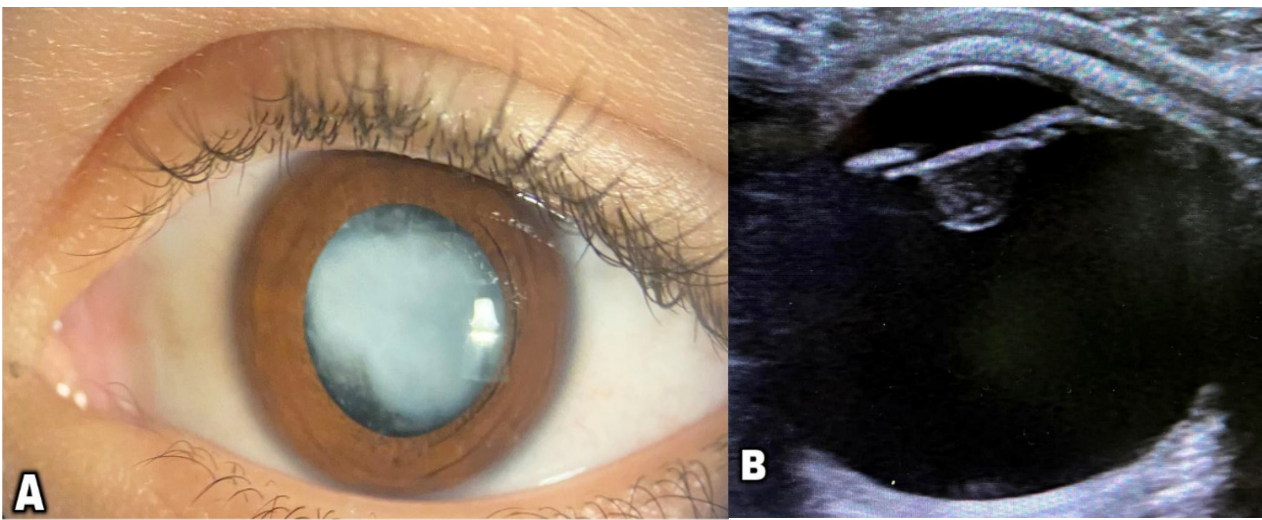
(A) Slit lamp examination of the left eye: congenital cataract; (B) Ultrasound image of the left eye: Conical deformation of the posterior surface of the lens suggesting a posterior lenticonus.
